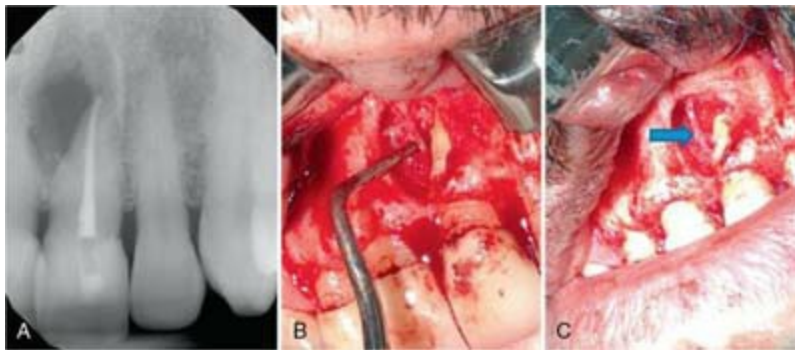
A, Radiograph demonstrating periradicular radiolucency associated with previously treated tooth #9. B–C, After full-thickness flap reflection, the nasopalatine neurovascular bundle was identified
